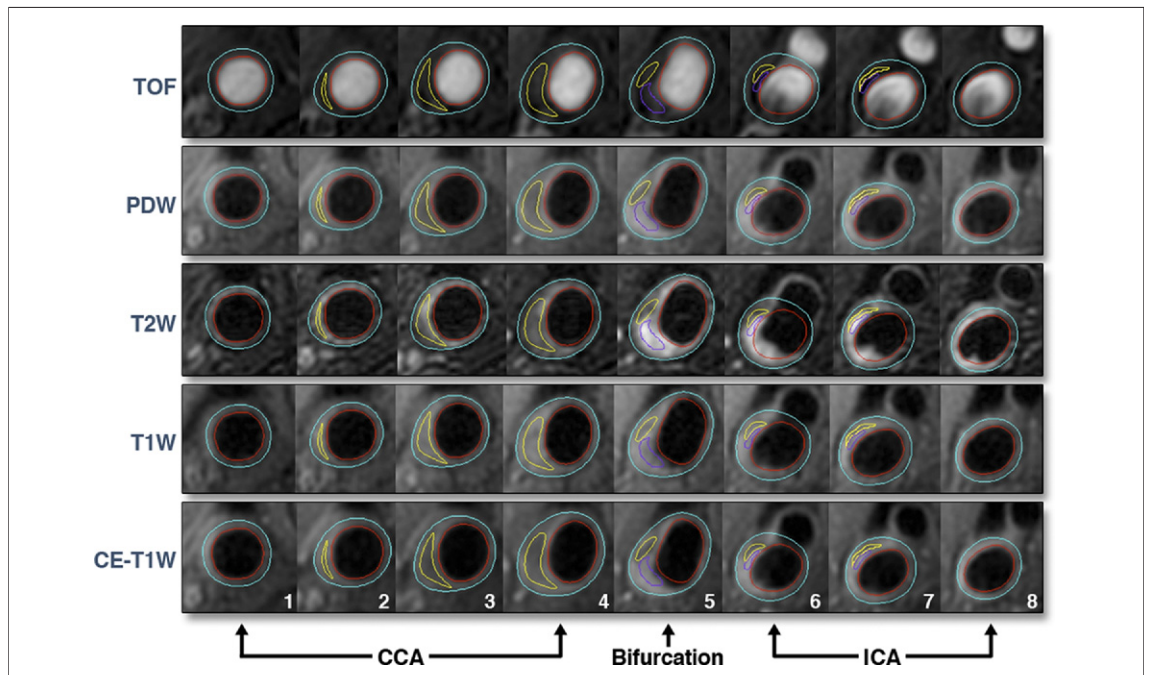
Example of Carotid Artery in Multicontrast MRI
